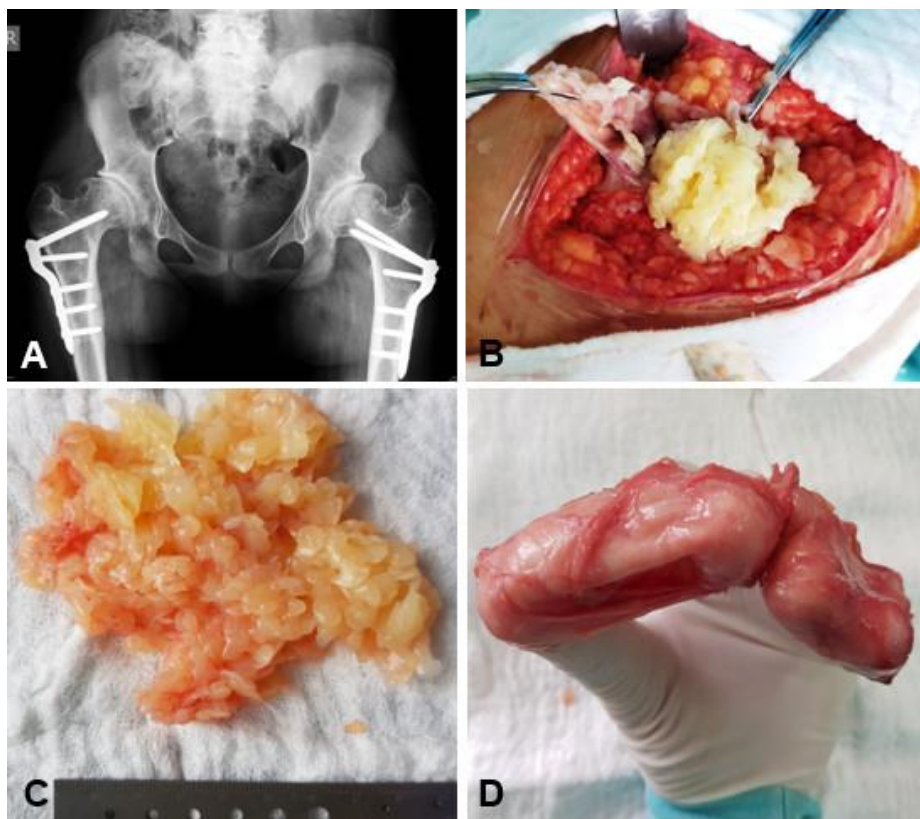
Figure №1 A. Conventional radiography (AP view) of the 17-year-old patient 6 years post bilateral varus osteotomies of the proximal femur. B. Intraoperative finding after surgical incision of the trochanteric bursa. C. The pathologic finding- round shaped whitish rice bodies with total mass of 160gr. D. The trochanteric bursa with pathologically thickened membrane and enlarged size.
